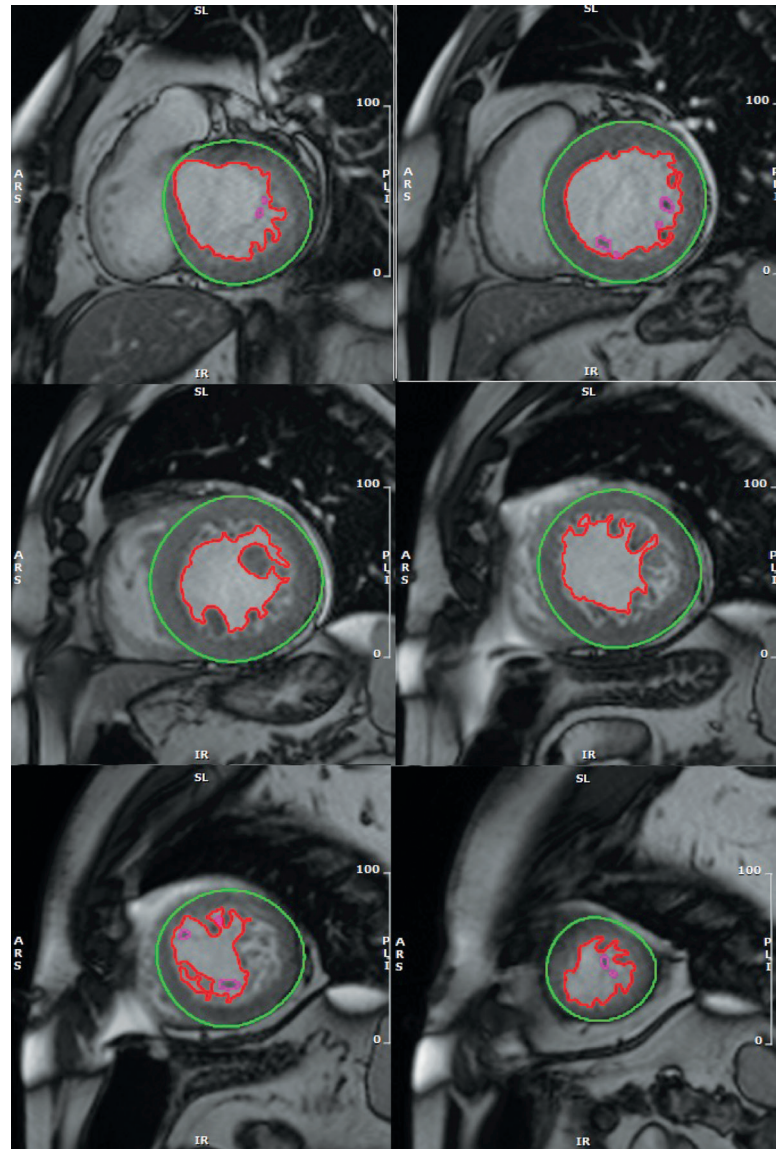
MRI of the heart. Dilated phenotype of NCCM with a marked systolic dysfunction (LVEF – 35%). Non-compacted myocardium of the lateral wall of the LV at the level of the middle and apex segments, $NC/C > 2.3$
